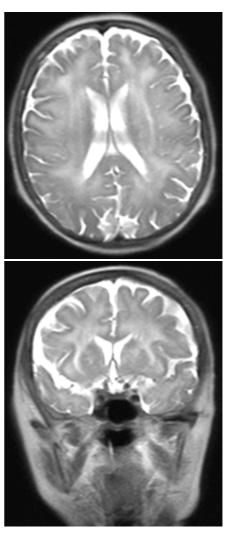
Magnetic Resonance Imaging with High T2/FLAIR signal of cerebral white matter with confluence in periventricular and deep regions as well as subcortical white matter mainly in frontal and temporal regions.
